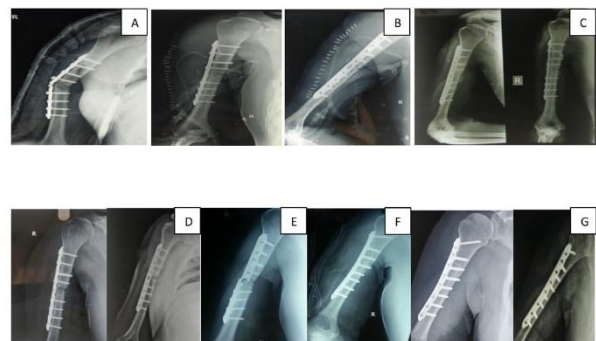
Recalcitrant case managed with compression plating with fibular strut grafting and iliac bone grafting: (A) X-ray showing implant failure of midshaft fracture humerus, (B) immediate post-operative X-ray after compression plating and iliac bone grafting, (C) X-ray at 1 month follow-up, (D) X-ray at 3 months showing no signs of union, (E) X-ray at 4 months follow-up depicting broken plate, (F) post-operative day 1 after revision plating with fibular strut and iliac graft (G) 5 month X-ray showing adequate radiological union and (H) 11 month follow-up depicting good outcome.
